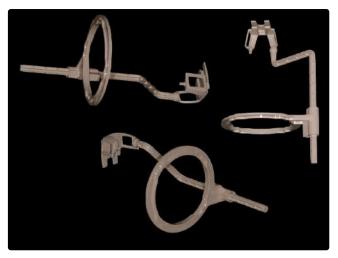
RINN endodontic centering device to perform intraoperative radiographs.
